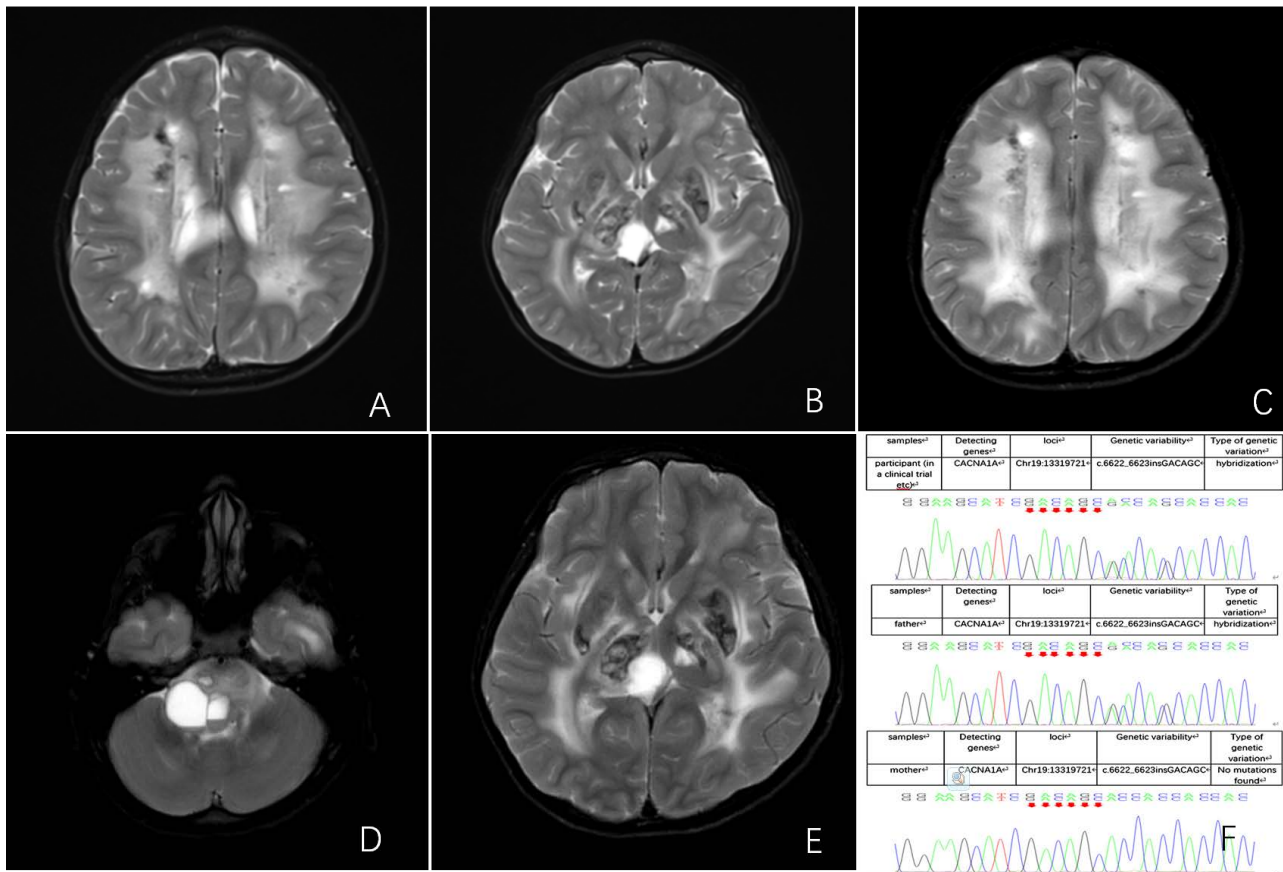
A and B: for 2020 cranial MRI scanning and diffusion-weighted imaging: 1. Diffuse abnormal signals in the medulla of bilateral cerebral hemispheres, bilateral basal ganglia thalamus region, brainstem, bilateral cerebellar hemispheres: metabolic disease possible, internal combination of calcification; 2. Cystic enlargement of the right ventricle, with insignificant changes above cysts to be discharged compared to the previous slice. C, D and E: for 2022 cranial MRI: Diffuse abnormal signals in the medulla of bilateral cerebral hemispheres, bilateral basal ganglia thalamic region, brainstem, and bilateral cerebellar hemispheres, with obvious progression of the brainstem lesion: metabolic disease is possible, with internal consolidation of calcification, cystic enlargement of the right ventricle, and cysts to be discharged; F: for the genetic test: heterozygous for the gene CACNA1A, de novo mutation, but the evidence of causation of this child's genetic test is insufficient, and the genetically-induced seizures are not considered.
